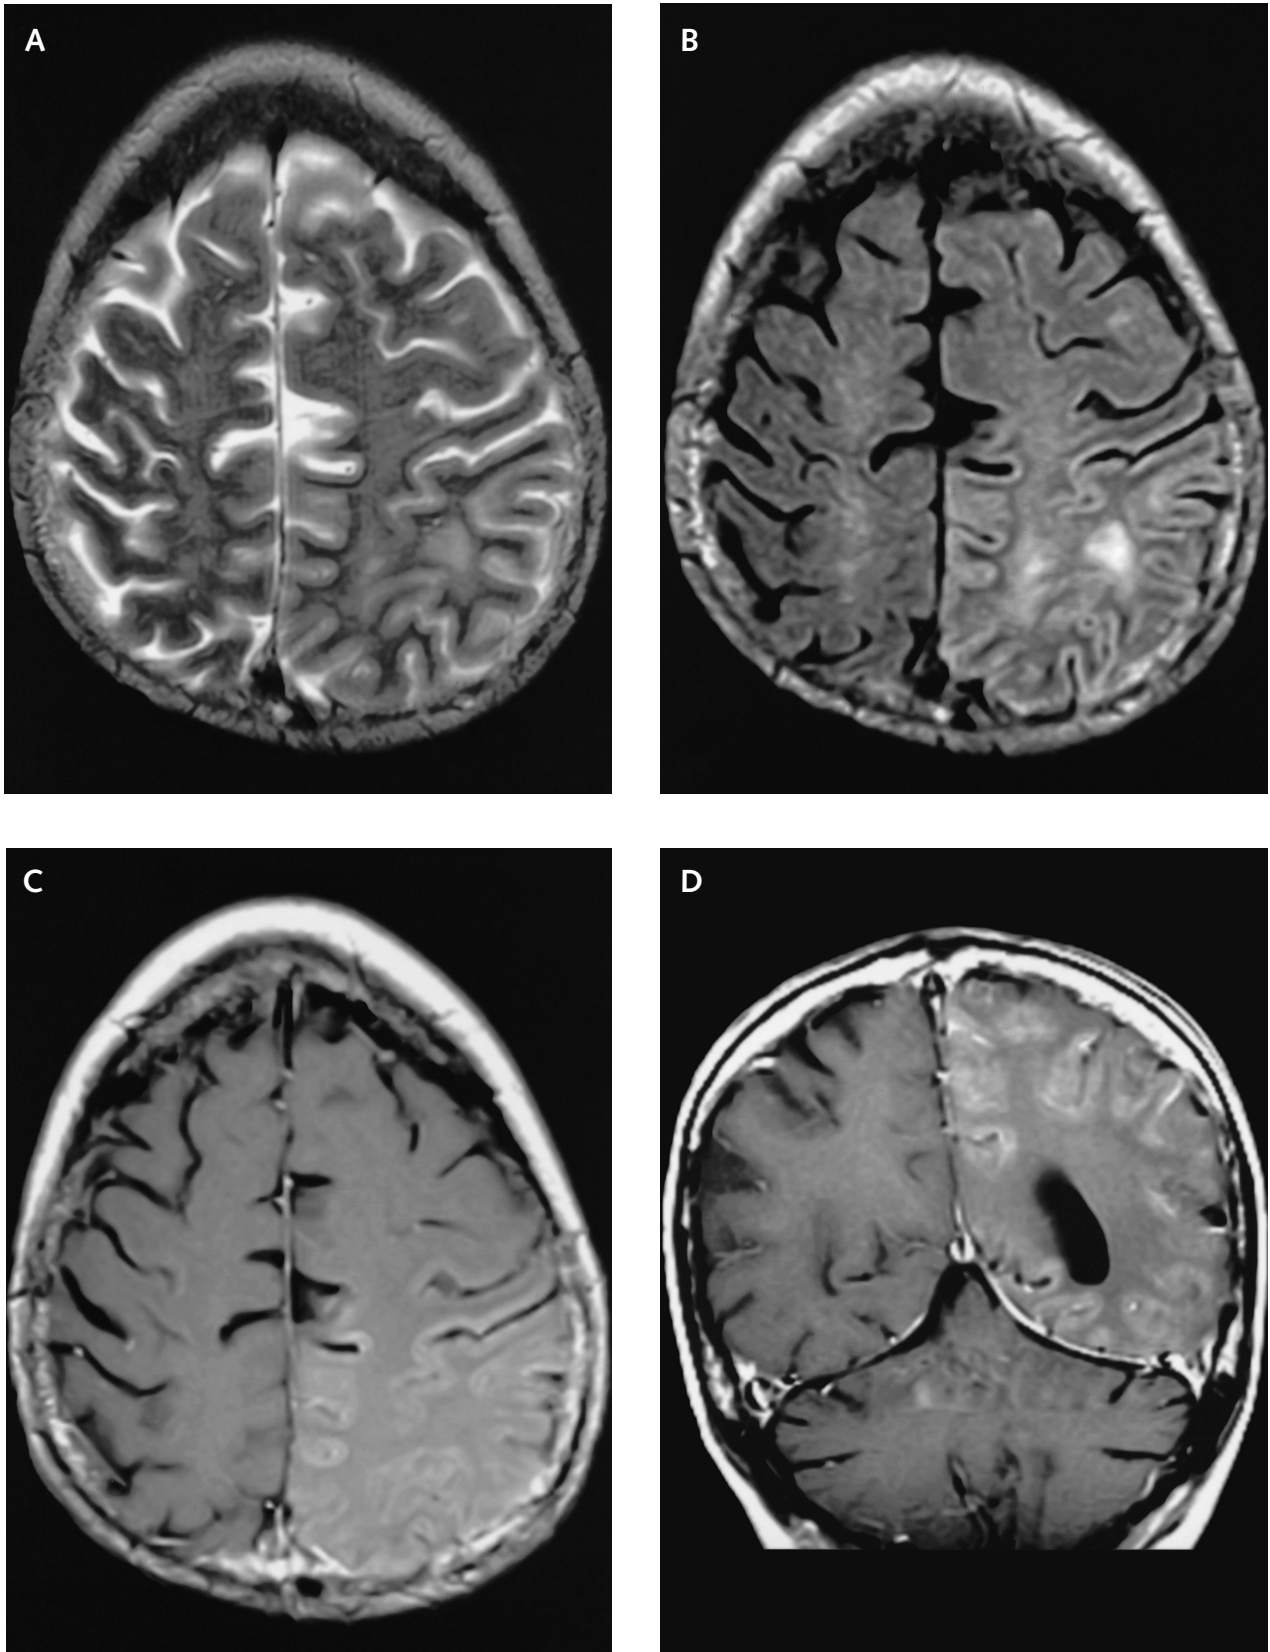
Patient 2—MRI brain scan 2 days post-ictus. Axial T2-weighted fast spin-echo (A) and fluid-attenuated, T2-weighted fast spin-echo (B) images demonstrate increased T2 signal intensity in the left fronto-parietal region near the vertex, most prominently involving the cortex. Axial (C) and coronal (D) T1-weighted images following gadolinium administration. Gyriform enhancement of the left posterior temporo-parieto-occipital cortex, including pre-central and post-central gyri, matching the T2 signal abnormality. Subtle, less extensive enhancement of right fronto-parietal cortex.
